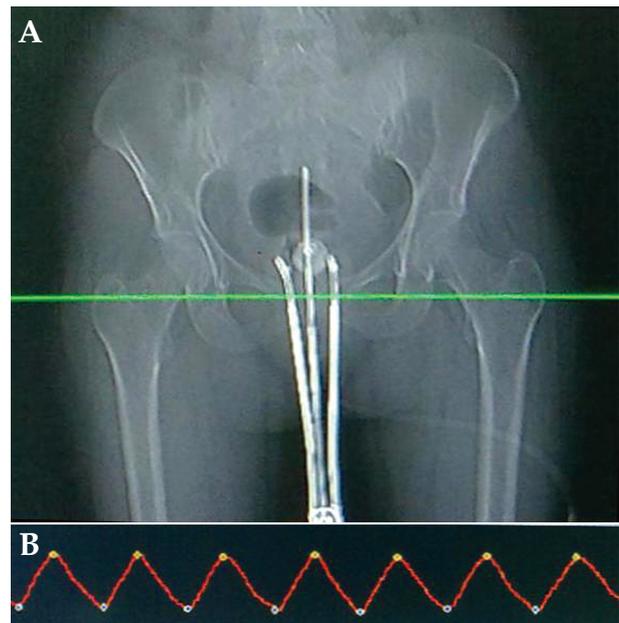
A) Topogram of a patient with applicator, B) Respiratory waveform displayed on Philips 4D CT console
